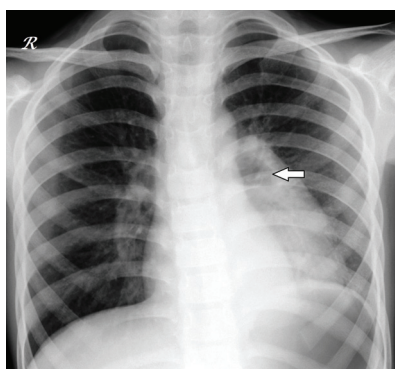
Chest radiograph in PA projection shows partial consolidation-collapse of left lower lobe with signs of internal cavitation (arrow) in a case of bacterial pneumonia.
